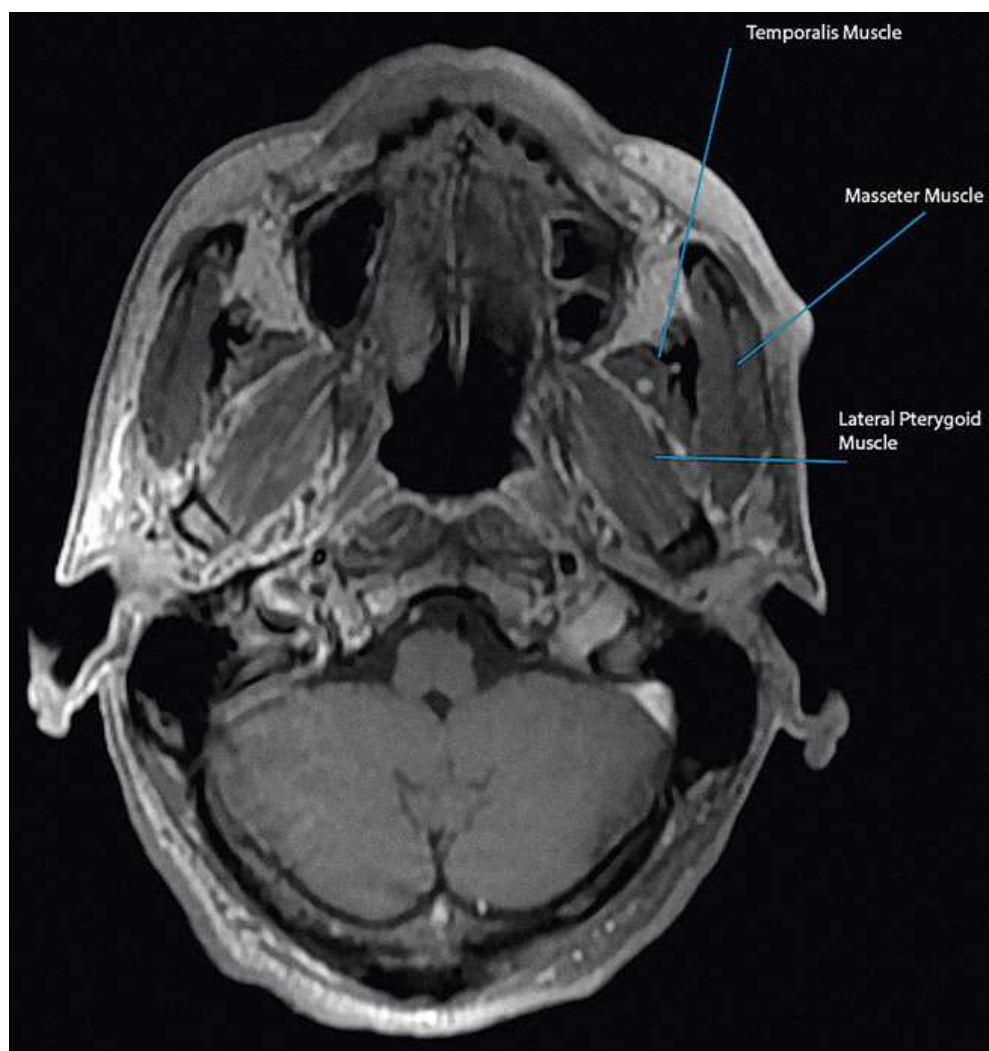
Axial T1-weighted MR image of the brain.
